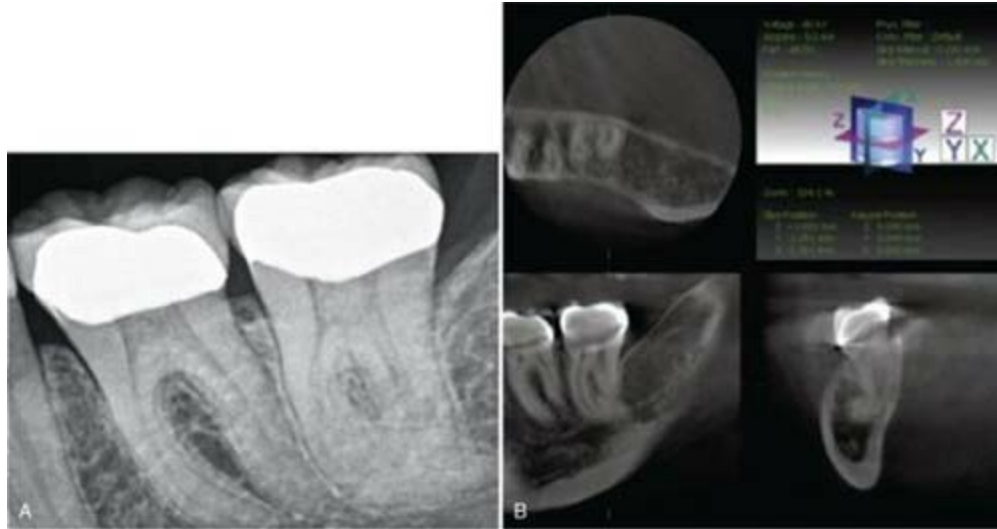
A, Mandibular left second molar referred for endodontic evaluation and possible treatment. This 2D radiograph reveals significant pulp stones and canal calcification developing not only in the coronal aspect of the root canal system, but also extending down the visible distal canal. The apical third of the canal system appears unusual and dilacerated. Cone-beam computed tomography (CBCT) would be beneficial in visualizing the root canal anatomy, to create the ideal endodontic access. B, Single slice of the CBCT image for the same tooth. Information about the direction of the root canal anatomy is provided in all three planes of the section: axial, coronal, and sagittal. Interestingly, the axial slice shows that the mesial lingual root actually traverses buccally as it approaches its terminal extent. This is valuable information for the clinician before the entire root canal system is cleaned and shaped; it may also establish a higher degree of treatment predictability.
